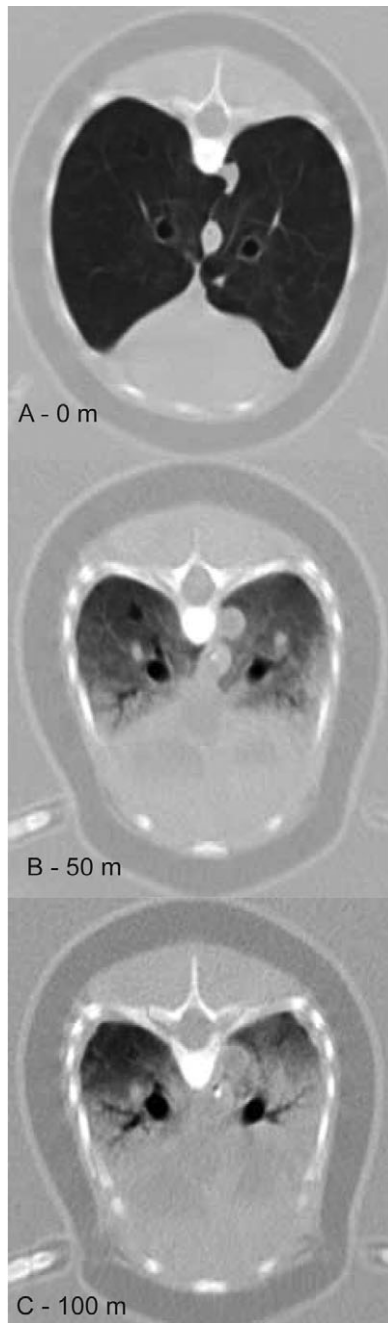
Computed tomography (CT) sections through the mid-thoracic region of the harbor porpoise at (A) 0, (B) 520 and (C) 1000 kPa (i.e. depth equivalents of 0, 50 and 100 m). The darker the tissue, the more gas it contains. The darkest quasi-circular structures are the bronchi, and these were excluded from the numerical volumes numerated in Fig. 4.
